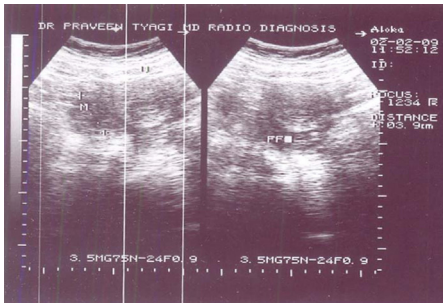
Ultra Sonography prior to surgery
